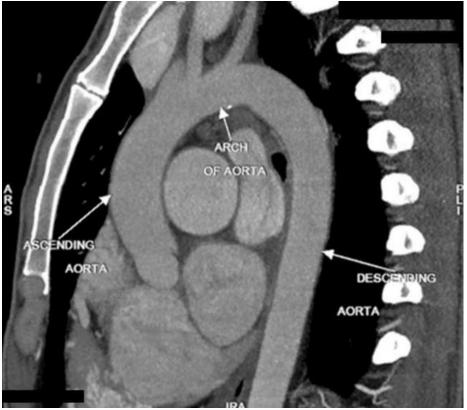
CT thorax sagittal view The aortic root, ascending aorta, arch of aorta and descending thoracic aorta are normal in caliber
